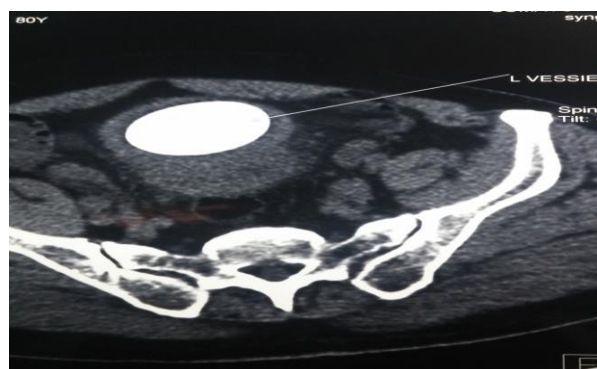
CT scan image showing a bladder stone.
